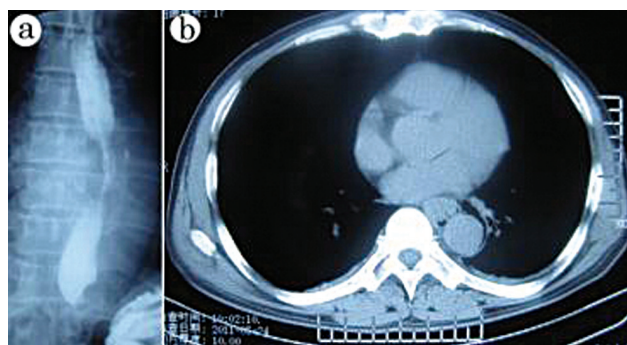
a. Irregular narrowing of the middle esophagus in barium swallow examination. b. Thickened middle esophageal wall, with pneumomediastinum and bilateral effusion in CT scan.
